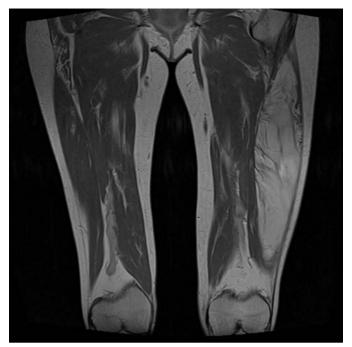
T1 MRI (fat is bright) showing a large, deep, intramuscular lipoma of the left thigh. It is made of largely bland fatty tissue. Although there is some streaking, there are no dark nodules to suggest an area of dedifferentiation. (Contrast with Figure 20.30)
